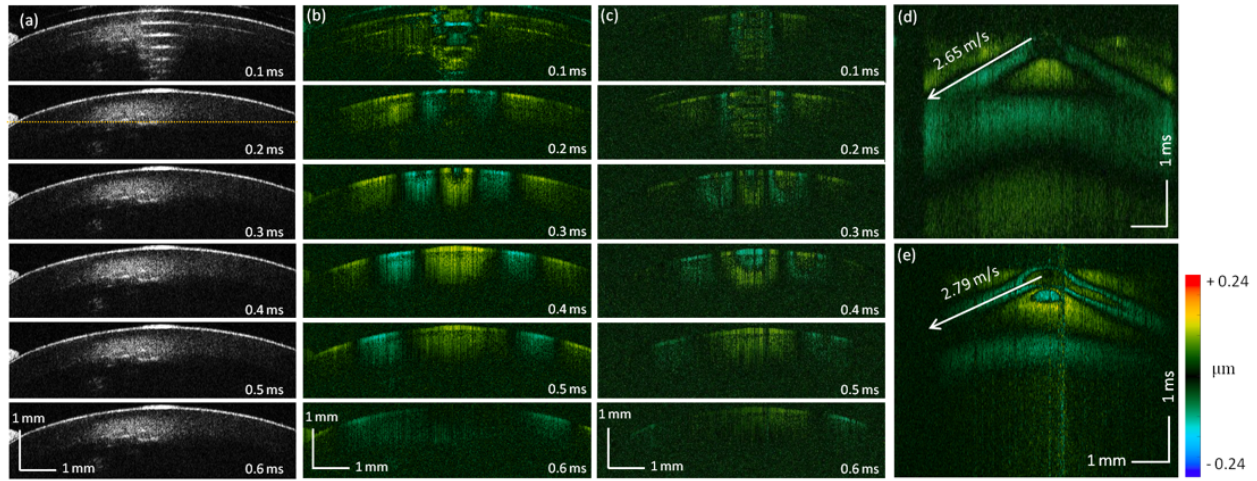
Ex vivo* cold cataract lens results. (a) Time-lapse OCT B-scan images of a normal lens. (b) Time-lapse Doppler OCT B-scans of a normal lens. (c) Time-lapse Doppler OCT B-scans of a cold cataract lens. (d) and (e) Spatiotemporal Doppler OCT of normal and cataract lens at a depth indicated by yellow dashed line in (a).
